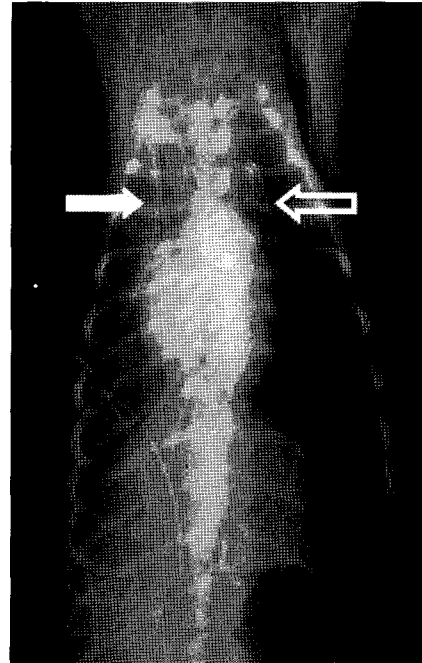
The magnitude of pleural air in left hemithorax is observed on ventrodorsal radiographic view. It caused the mediastinal shift to the right. The right (closed arrow) and left (open arrow) chest tube were also present.
